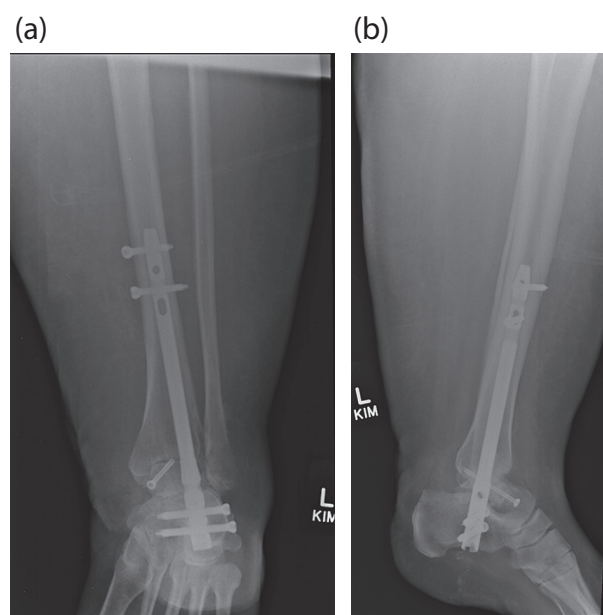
Plain radiographs on discharge six weeks post-surgical intervention. No evidence of avascular necrosis of the talus and fixation remains as was achieved intraoperatively: a) anteroposterior view; b) lateral view.
